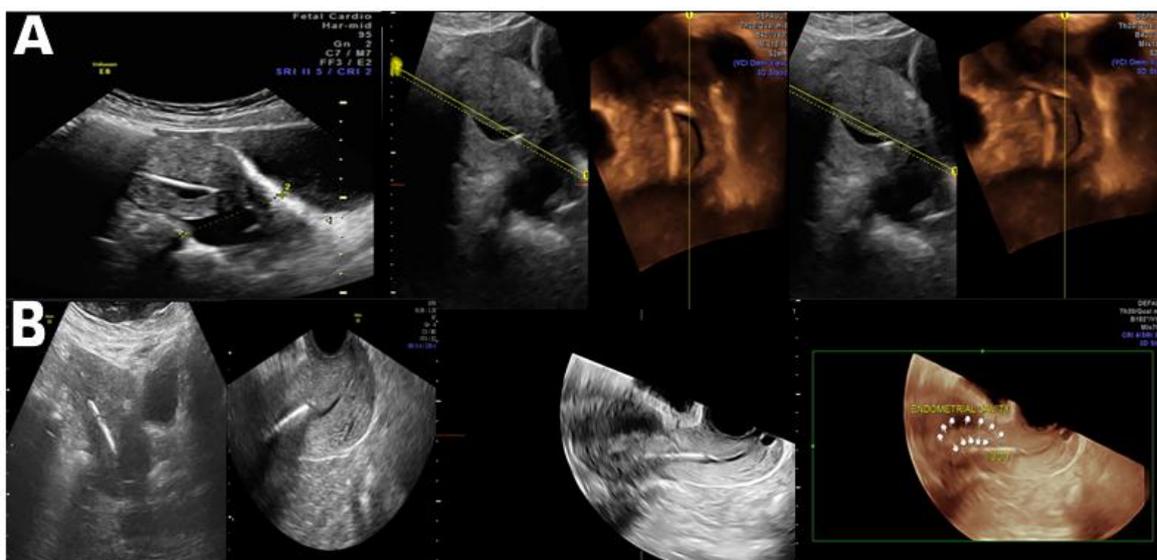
2D,3D and Omniveiw VCI sonographic images for a two cases with markedly impeded IUCD within the myometrium and misdiagnosed by the 2D images to be in place, the 1st case (A) shows completely impeded IUCD within the myometrium parallel to the endometrial cavity that containing fluid rim , the second case (B) shows impeded arms and most of the IUCD stem within the myometrium apart from short segment of the stem seen within the endometrial cavity near the internal cervical os
